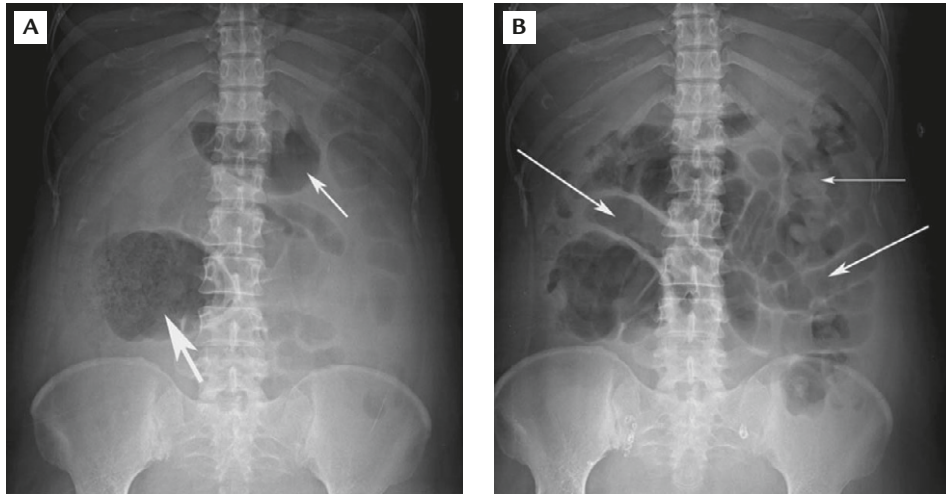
Radiographs of Case 1 show: (A) a distended stomach (small arrow) and cecum (11 cm in diameter, large arrow) with stool inside it; (B) 1 day later, passage of stool to the descending colon (small arrow) and distension of the small intestine (large arrows).
